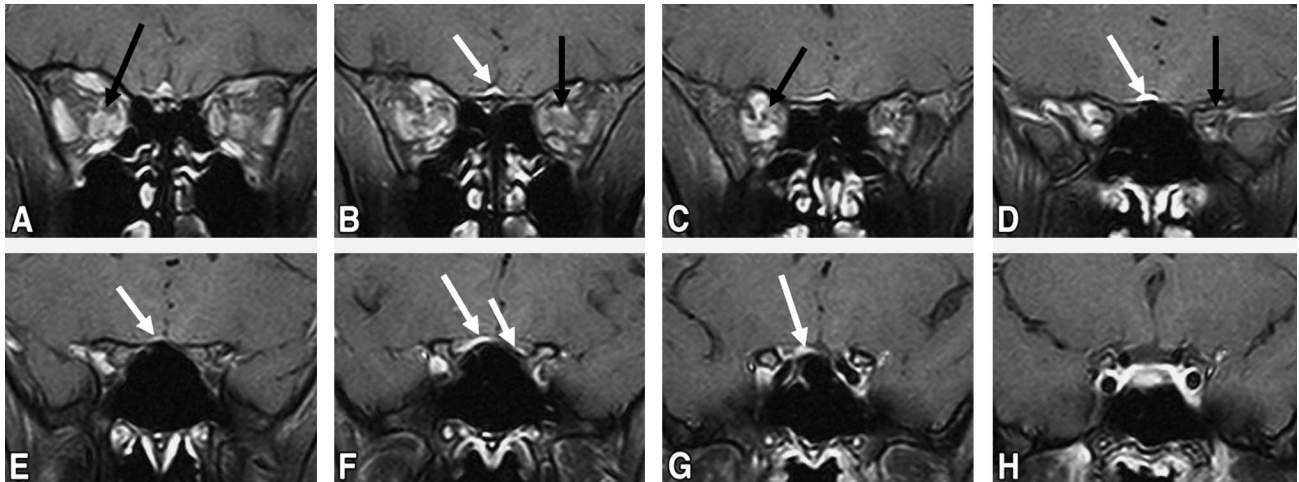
Postcontrast coronal orbital MRI shows enhancing lesions that encase the orbital optic nerves (*black arrows*) and extend to partially encase their prechiasmatic portions (*white arrows*).
